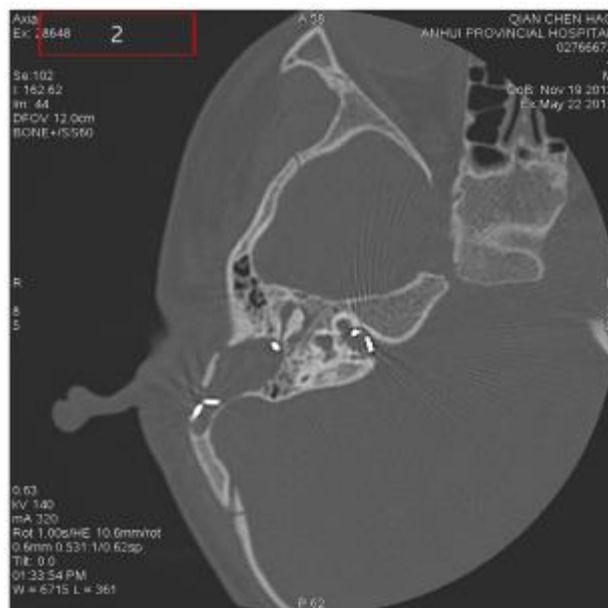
The result of CT scans showed proper placement of the cochlear implant electrode array.
